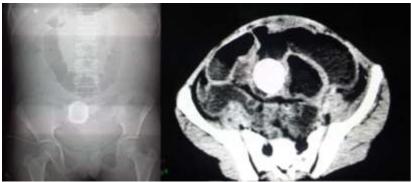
Abdominal X-ray film shows the calcified mass in the right pelvis CT shows an ovoid, hyperdense calcified lesion (6×4×4 cm) in the ileum lumen
